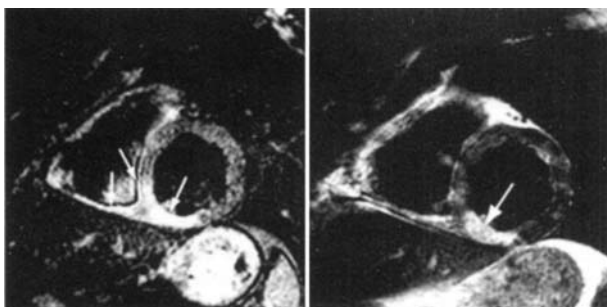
Right ventricular involvement in inferior infarction (day 3 after the clinical event). Left panel: Signal increase in a T2-weighted MR image in a short axis view reflecting myocardial edema (arrows). Right panel: Late contrast enhancement after administration of Gd-DTPA with mostly intramural extent (arrow).
